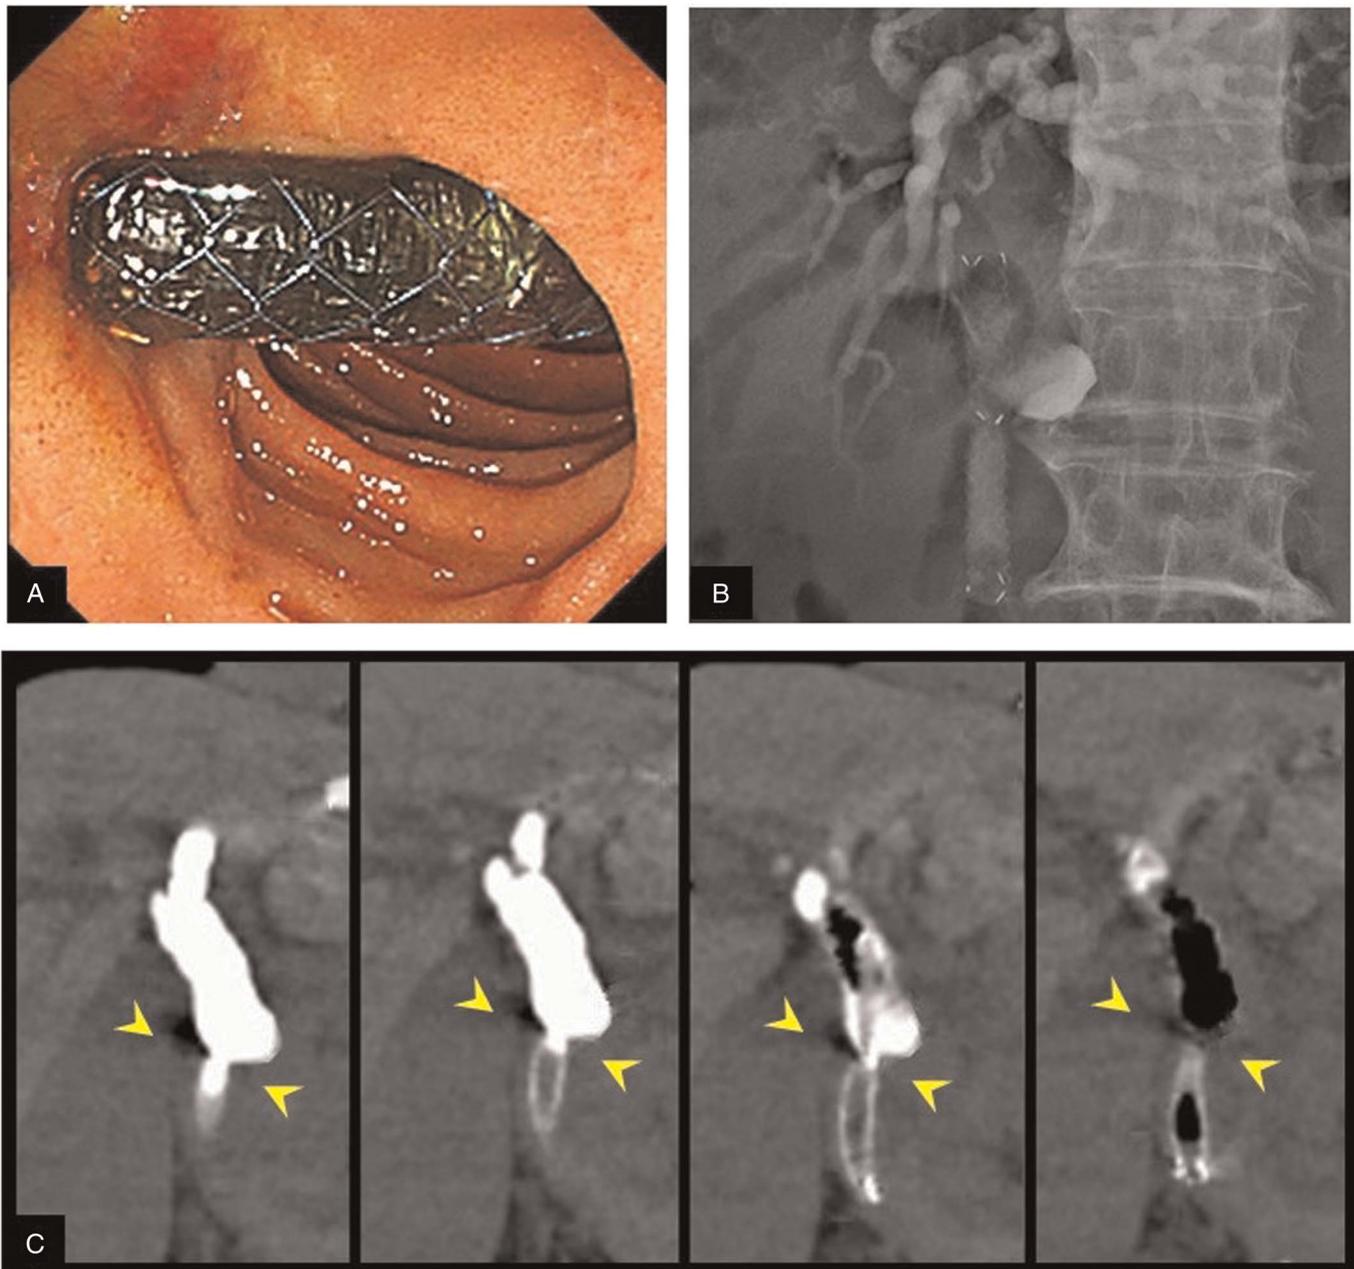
Imaging findings after the stent placement. A, Endoscopic image. B, Fluoroscopic image. C, On-site abdominal computed tomography immediately after the procedure (coronal image) showing no contrast medium leakage into the peristula abdominal cavity (between arrowheads).
